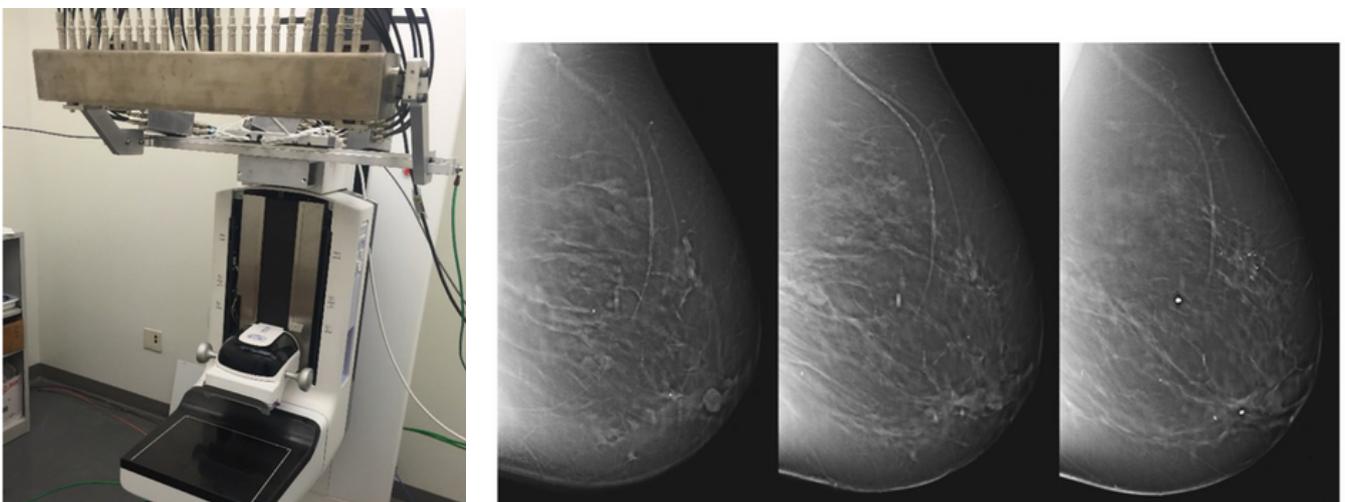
Left: 2nd generation stationary digital breast tomosynthesis (s-DBT) system with integrated CNT based distributed source array. The system comprises of 21 x-ray focal spots which can be electronically controlled instantaneously [11]. Right: Sample mediolateral-oblique views obtained by stationary digital breast tomosynthesis. These slices are a part of the reconstructed image stack generated from 15 X-ray projections. The reader scrolls through the slices to visualize the three-dimensional anatomy and pathology [6].
